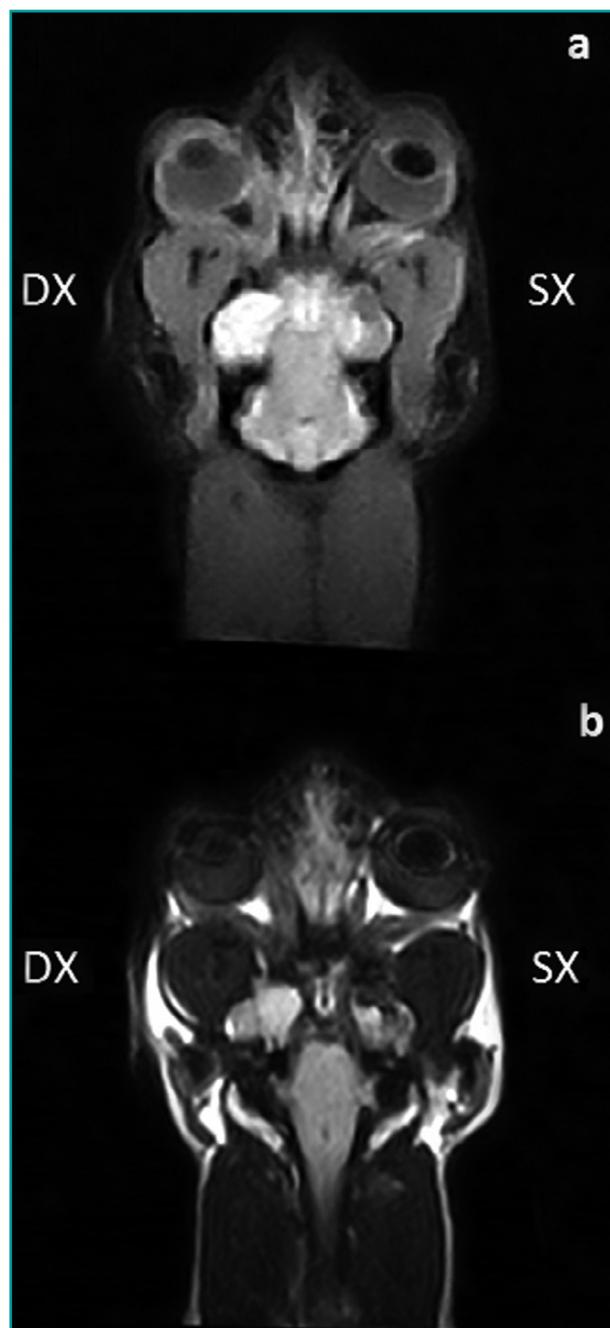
MRI study, dorsal scans. (a) STIR-weighted images: the right globe appears compressed and there is evident hyperintensity of the right scleral, episcleral and orbital tissues compared to the contralateral tissues. (b) Images acquired with the FLAIR technique: decrease in adipose tissue in the right orbit compared to the left.
